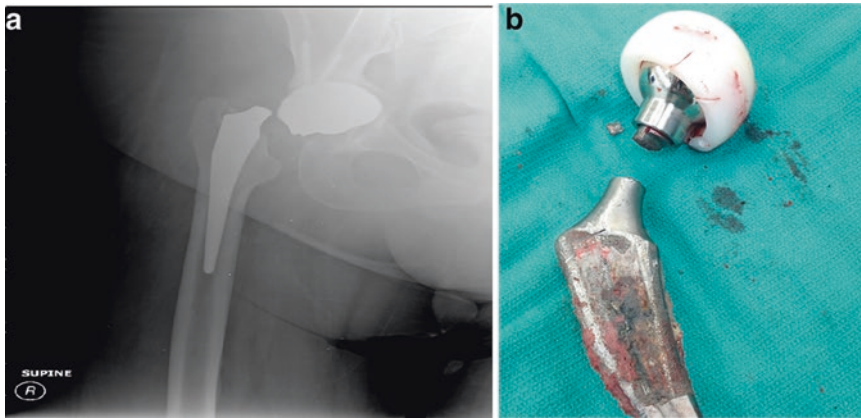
(a) AP radiograph of the right hip demonstrating a fracture of the femoral component at the neck of the implant, secondary to impingement with resultant femoral stem notching. (b) Intraoperative image of the broken implant
